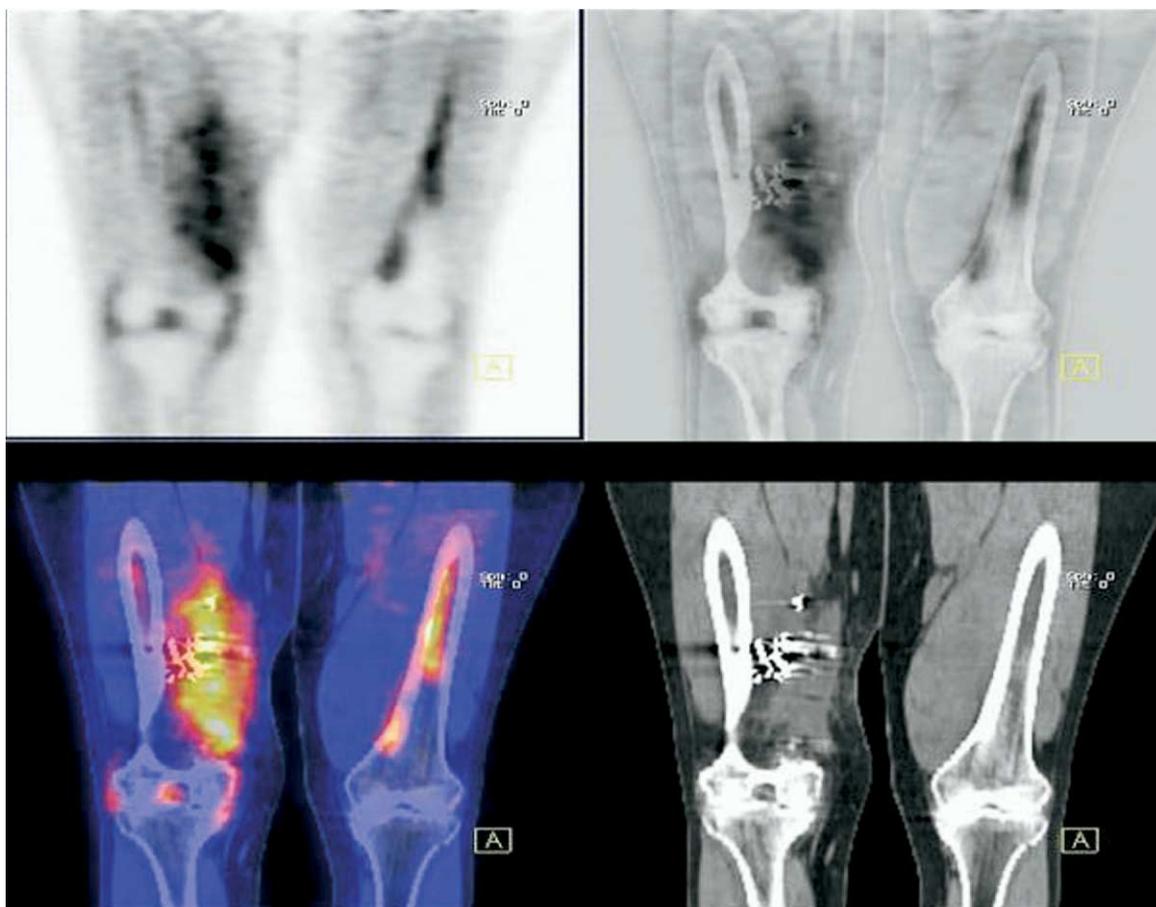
Shown is a 40-year-old male with right medial thigh angiosarcoma previously treated with resection. PET-CT shows hypermetabolic recurrent tumor in the surgical bed confirmed by biopsy. (Color version of figure is available online.)
